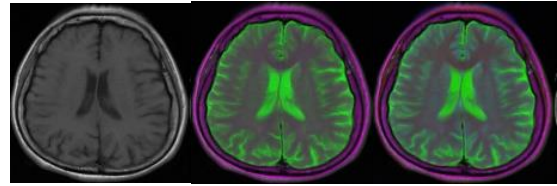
Example of T1W [left], the T1W-T2W [center], and T1W-T2W-FLAIR images [right].
